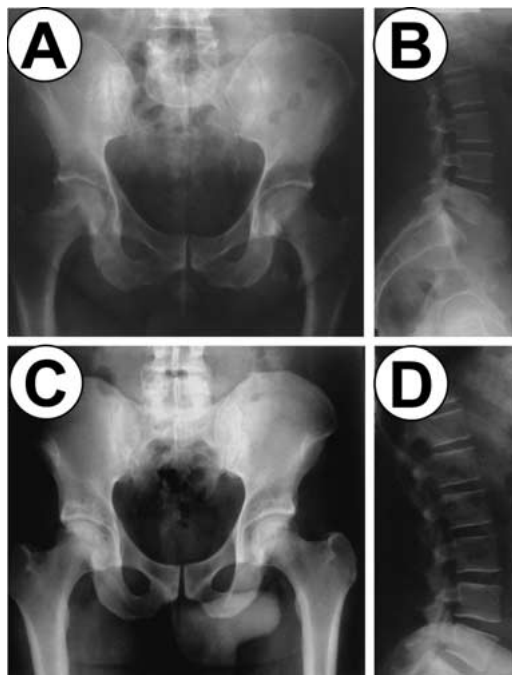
Radiographic analysis of relatives. (A) Pelvis and (B) lateral view of lumbar spine of the father. (C) Pelvis and (D) lateral view of lumbar spine of the first grade cousin. Note diffuse sclerosis in (C) and normal pattern in (A), (B) and (D).
